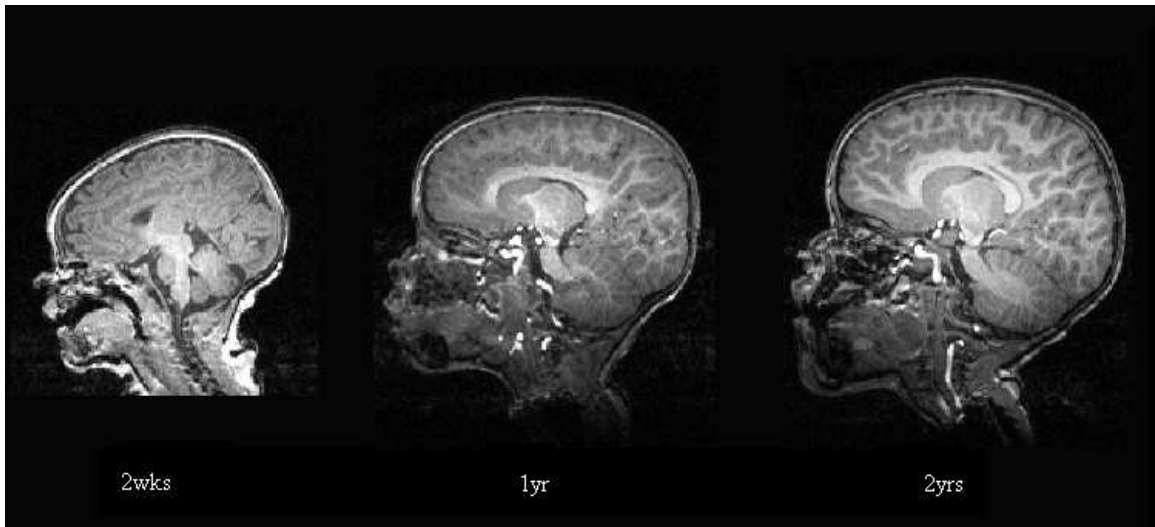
Representative T1-weighted MP-RAGE images are shown for 2wk, 1yr and 2yrs old children.
